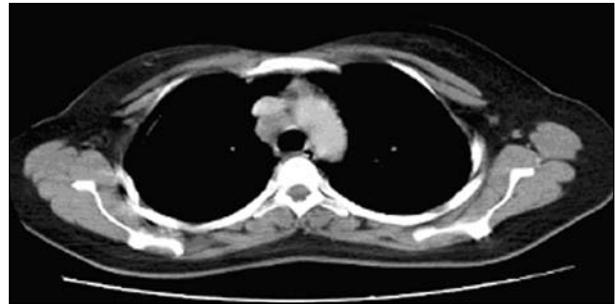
The pre-treatment CT scan of the thorax showed multiple subcarinal and peri-tracheal lymph nodes, the largest about 1.5 cm in size. However, none were in direct contact with the oesophagus, and there was no evidence of pulmonary disease.
